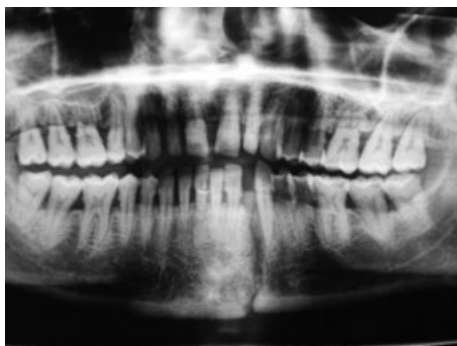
A digital panoramic radiograph showing a parasymphysal fracture.
